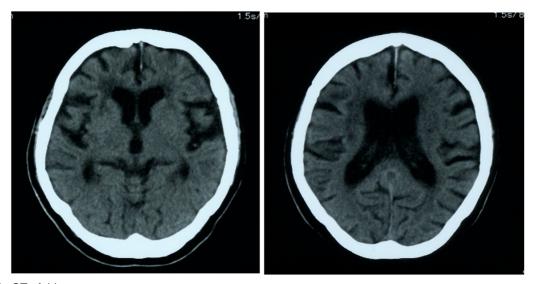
brain CT of this case.
